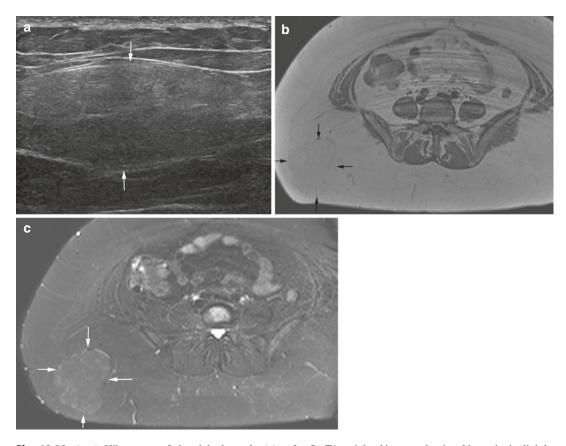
(a–c) Hibernoma of the right buttock. (a) Ultrasound. (b) Axial SE T1-weighted MR image. (c) Axial fat-suppressed SE T2-weighted MR image. The mass (*arrows*) shows predominant fat signal on ultrasound and MR images but not identical to the surrounding
